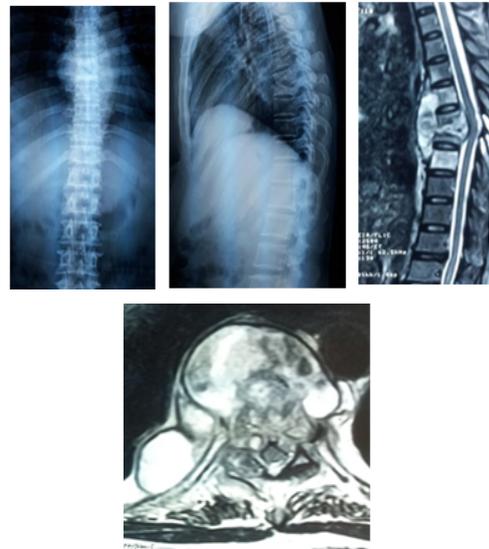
(A-F): 35 year old male with tuberculous spondylodiscitis T7-8. (A-B) antero-posterior and lateral radiographs showing destruction of vertebral bodies T7-8. (C-D) Sagittal and axial MR images showing collapse of vertebral bodies with subsequent kyphosis and spinal canal compromise. (E-F) Post-operative images showing restoration of sagittal balance and posterior instrumentation with pedicle screws and rods.
